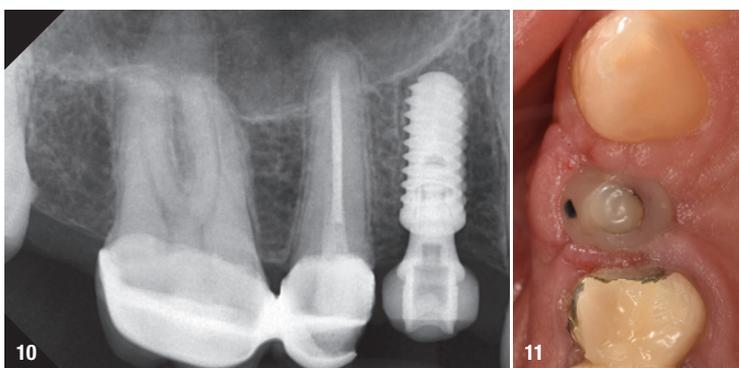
Immediate post-op radiograph. Fig. 11: Suture removal after one week, showing satisfactory healing.
